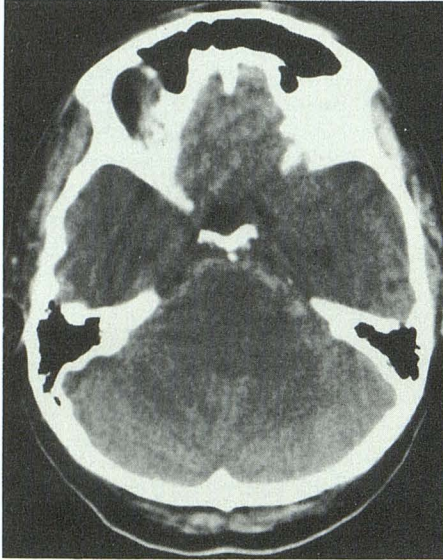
CT scan shows long, thin layer of blood in prepontine cistern.
